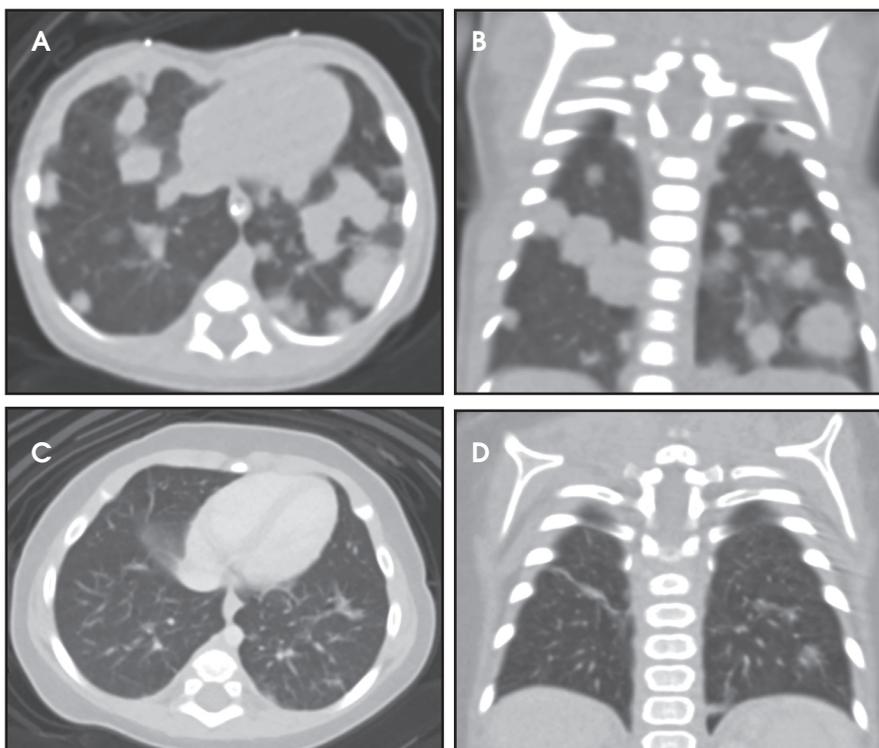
Axial and coronal CT images (A, B) obtained 5 days after birth demonstrate numerous bilateral pulmonary masses of varying sizes. Axial and coronal CT images (C, D) performed approximately 6 months after initial chest CT demonstrates significant regression of lesions.
